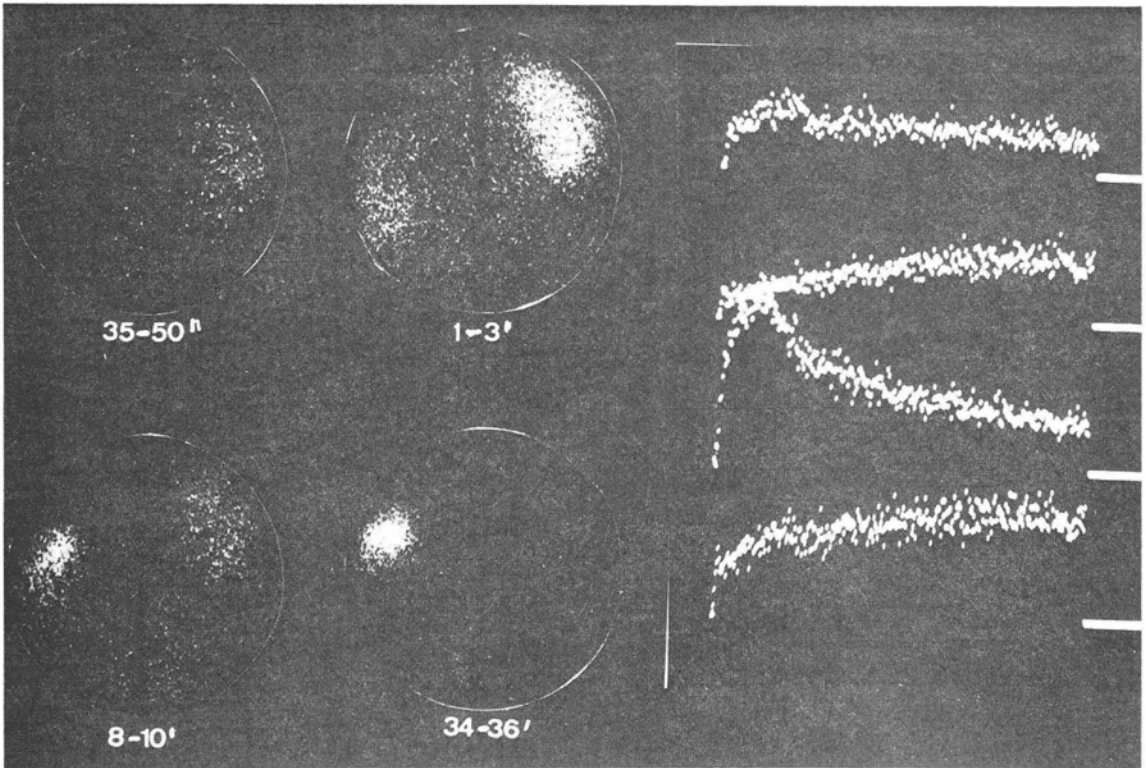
Serial scintigraphy and functional analysis of the left lower and upper pole, the right and the left kidney (from bottom to top) after 500 μ Ci ^{131}I -o-Iodohippuric acid in pyelonephritis and pelvic concrement of the left kidney: reduced inflow and no evacuation on the left upper pole, the renogram of the left side is mainly influenced by the slope of the radioactivity in the left upper pole.
